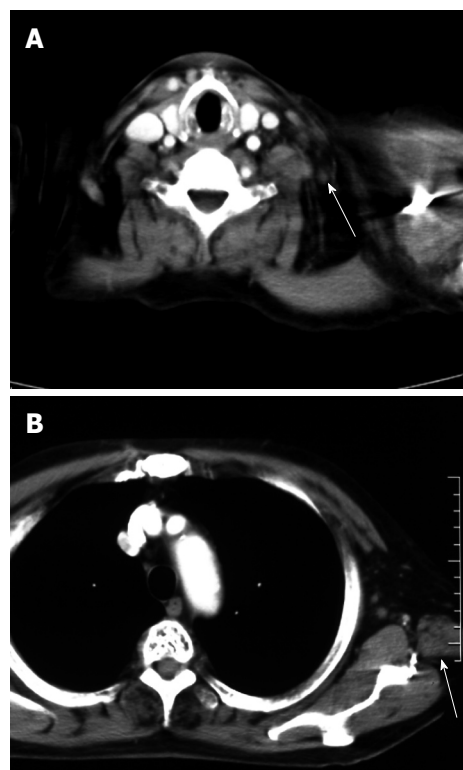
CT shows a Virchow's (A) and an axillary lymph node (B) which were reduced remarkably in size after treatment.
